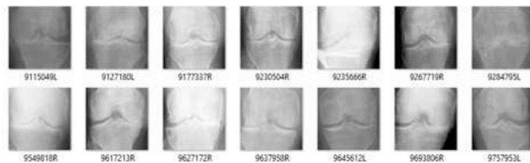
X-rays of Severe
